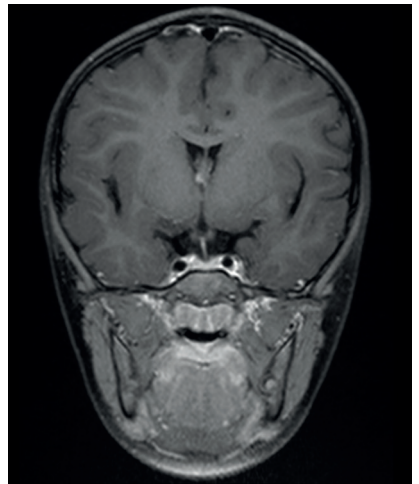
The second-year followed up of T1-weighted contrast of MRI of the brain (coronal)
